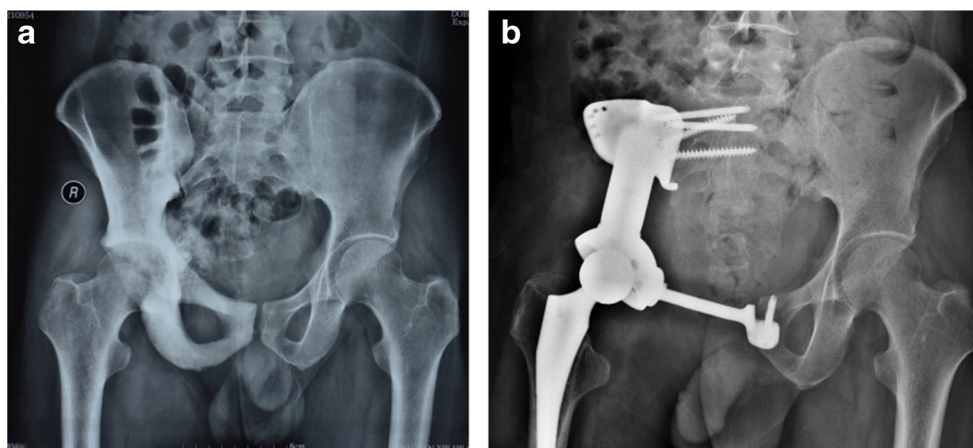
Plain radiography obtained from a 41-year-old male patient with a chondrosarcoma involving the ilium, pubis and ischium. A patient-specific 3D-printed hemipelvic prosthesis was implanted after *en bloc* resection of the tumour. (a) Before surgery. (b) Twelve months after surgery
